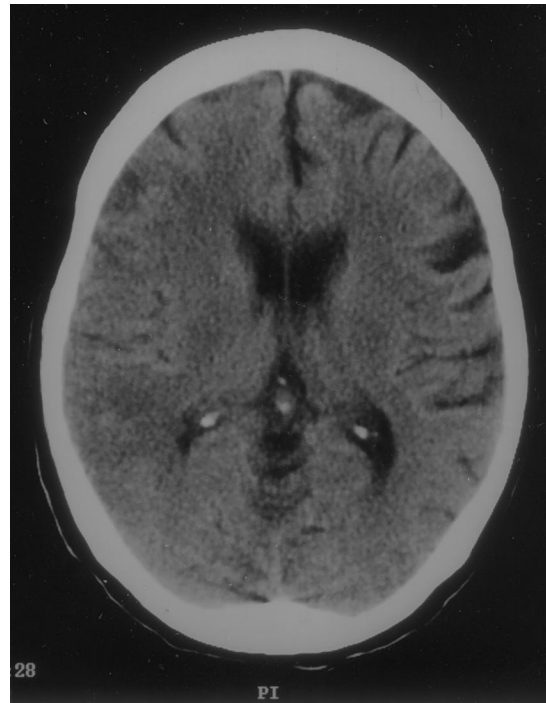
Unenhanced CT scan of head shows right hemispheric swelling and effacement of gyri on that side. Free parenchymal air is seen in the subfrontal region.
